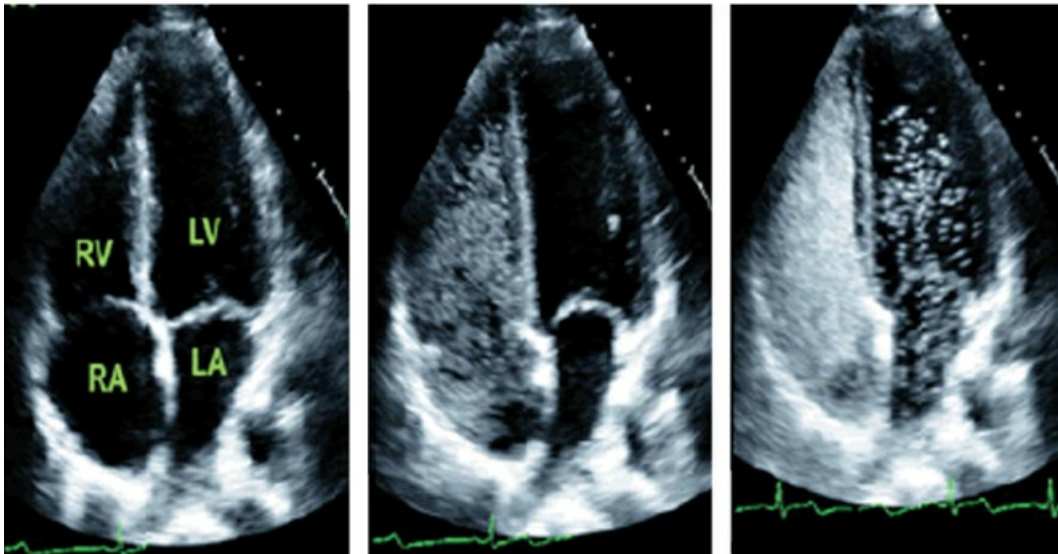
Transesophageal echocardiography in a patient with acute ischemic stroke, showing microbubbles (from the injection of agitated saline) moving from the right to left side of the heart. This is evidence of a right-to-left shunt from a patent foramen ovale. Images adapted from Reference 26.
